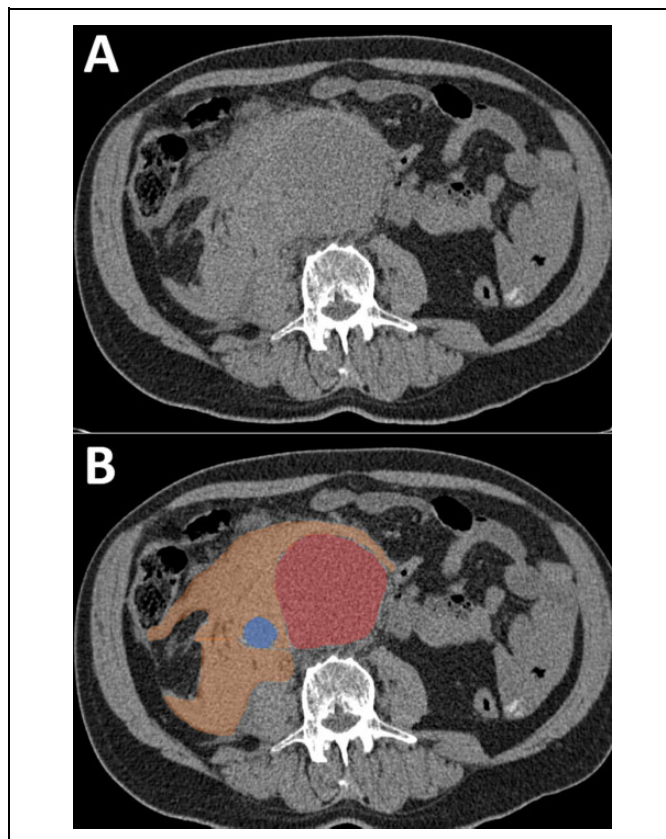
Abdominal computed tomography image of a ruptured AAA (A) alongside the same image where the dilated aorta is highlighted in red, the inferior vena cava in blue, and hemorrhage in orange (B). Maximum aneurysm diameter = 5.8 cm. Computed tomography imaging was done with intravenous contrast material. AAA indicates abdominal aortic aneurysm.
